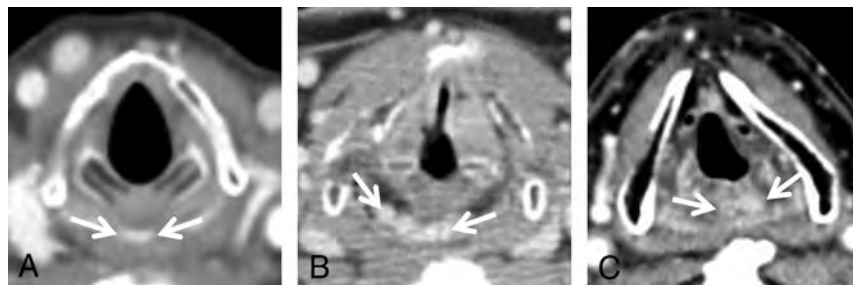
Axial contrast-enhanced neck CT images obtained in 3 different patients demonstrate representative images of the PCVP (arrows, A–C) at the cricoid cartilage level (A), the arytenoid cartilage level (B), and the supra-arytenoid level (C).
